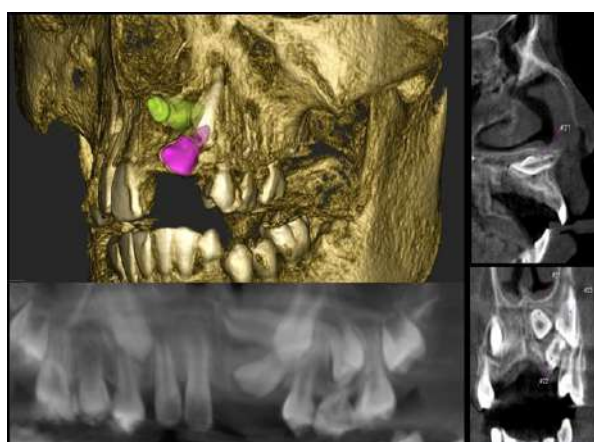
3D reconstruction, panoramic reconstruction, sagittal and coronal view of 3D CBCT images with medium FOV of 8-year-old male patient showing location and inclination of impacted teeth #21 and #22
